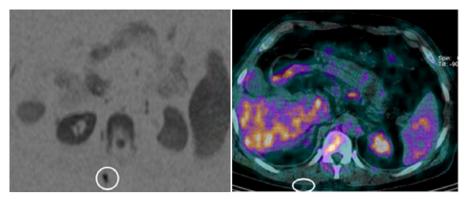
42 years old man. On the left: lumbar subcutaneous metastatic node (white circle) as seen by DW-MRI. On the right: the corresponding PET-CT image on which the node is not visible because of the lack of <sup>18</sup>FDG uptake.
